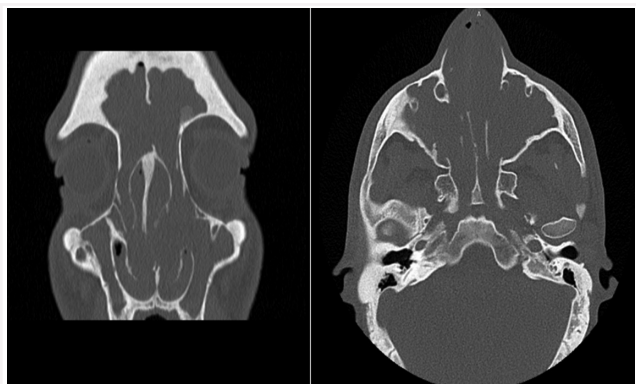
CT image of the same patient.
